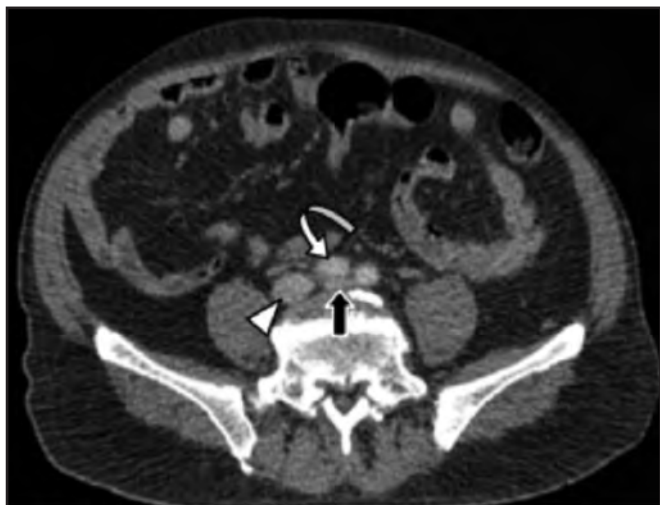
Axial contrast-enhanced CT image showed slit-like appearance of left common iliac vein (black arrow) due to compression by the overlying right common iliac artery (curved white arrow). The right common iliac vein (white arrowhead) was normal in calibre and patent
